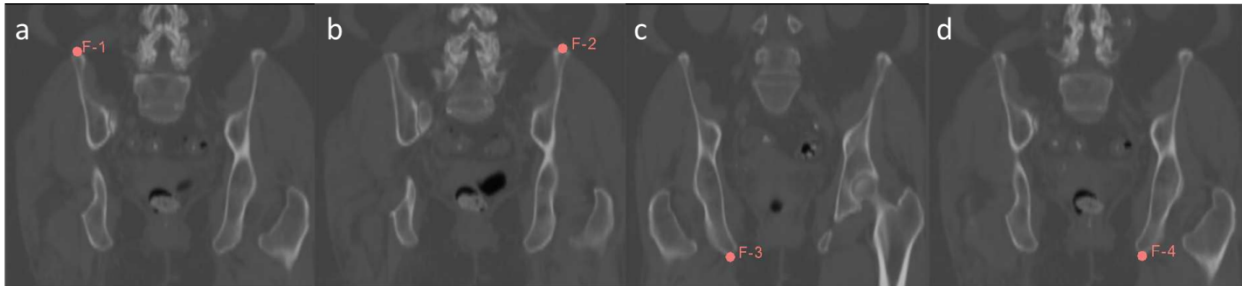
Landmarks placed on CT image volumes to assist alignment.
